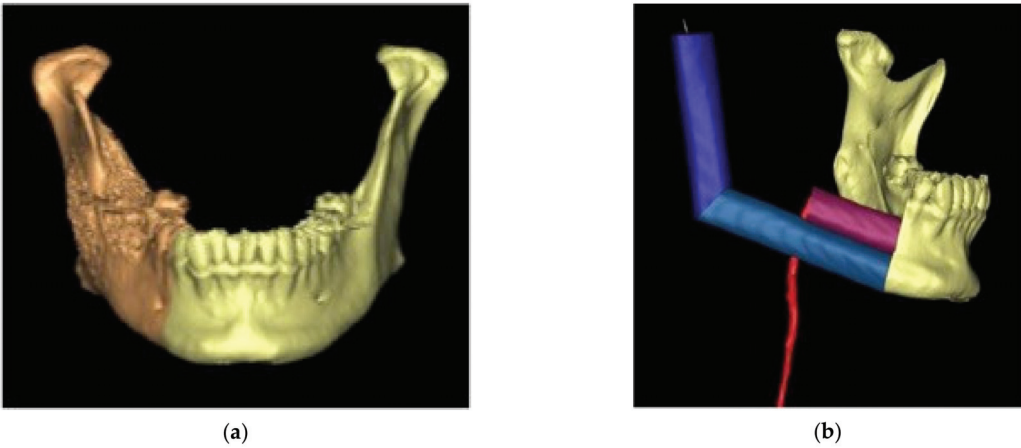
(a,b): Virtual surgical planning on CT images.
